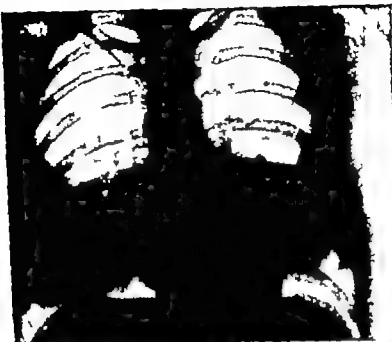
Chest radiography (4.3.63) Small bilateral, perihilar confluent densities and dilatation of the pulmonary arteries, mainly on the left.
